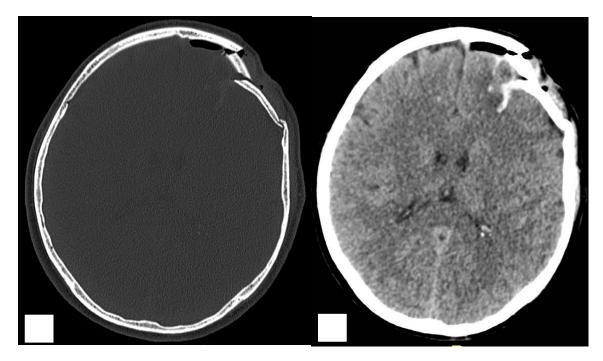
Axial plain CT brain of a 51-year old patient showing (a) bone window; comminuted and depressed fracture at the left frontal and (b) brain window; subarachnoid and intraparenchyma haemorrhage.
